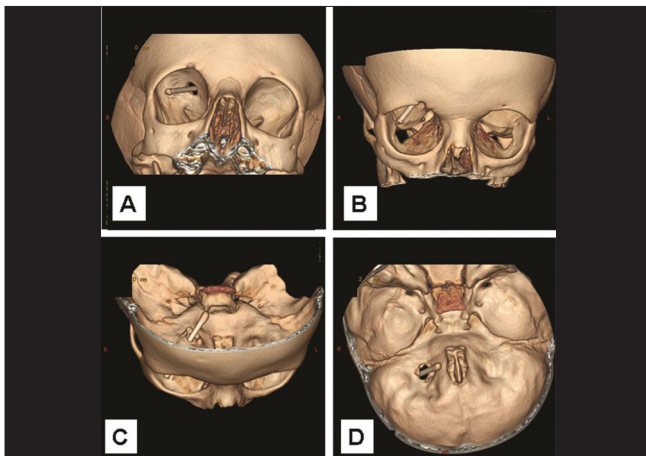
A-D Three-dimensional computed tomography scan showing the trajectory of the pencil. The pencil had penetrated the right frontal lobe through the orbital roof causing a defect in the dura. The tip of the pencil was just anterior to the anterior horn of the lateral ventricle. There was no disruption of major cerebral blood vessels
